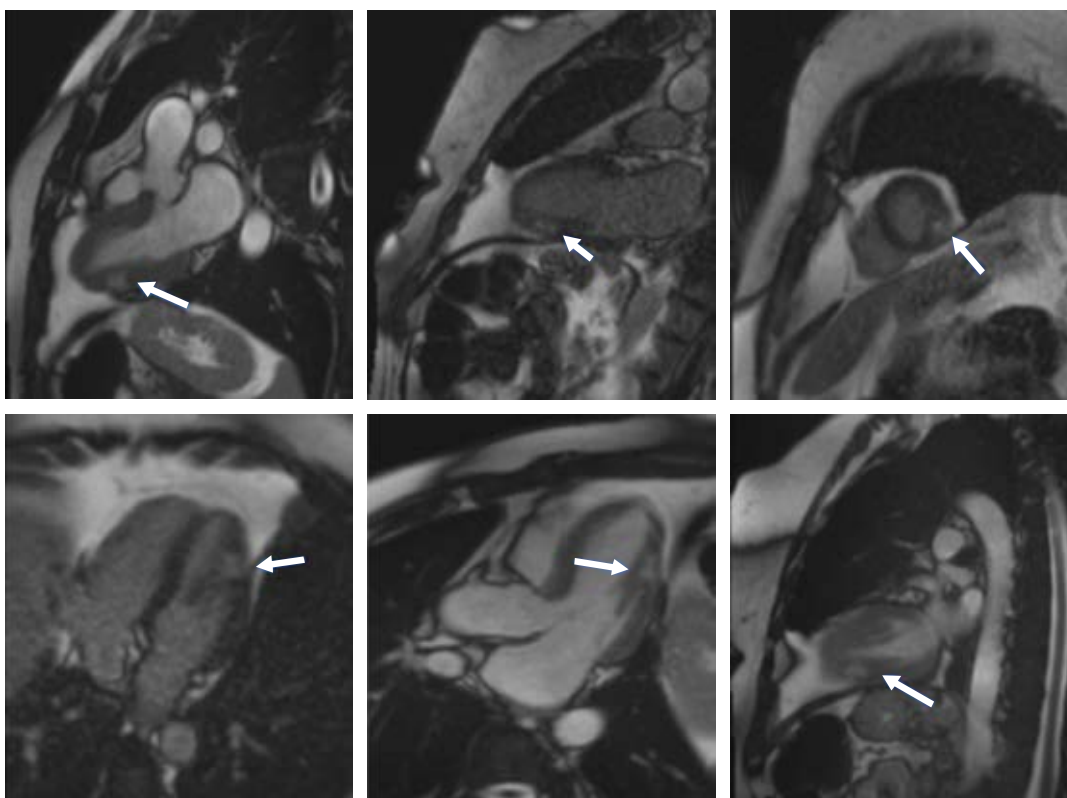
Cardiac magnetic resonance imaging. Zone of focal late gadolinium enhancement compatible with acute myocarditis (arrows).
